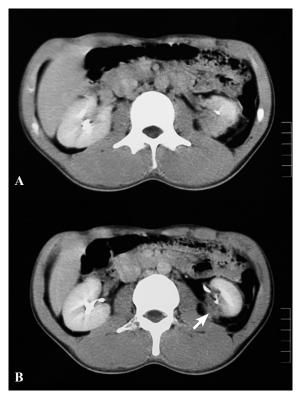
CT scan abdomen with contrast in three months after the trauma. A, the size of the left renal is still in good condition with regular surface. B, Hypodense is identified in the lower renal extremity which typical of parenchymal scar (arrow), while perirenal hematoma is no longer found.
